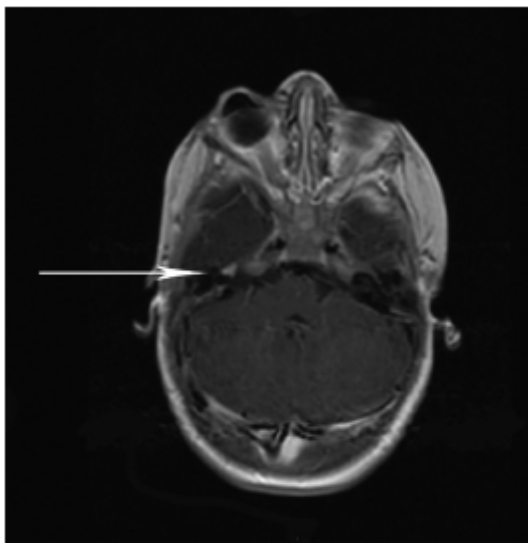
Magnetic resonance imaging (T1) post contrast show the lesion extending from the right geniculate body along the facial nerve to the level of the right stylomastoid foramen (arrows).
